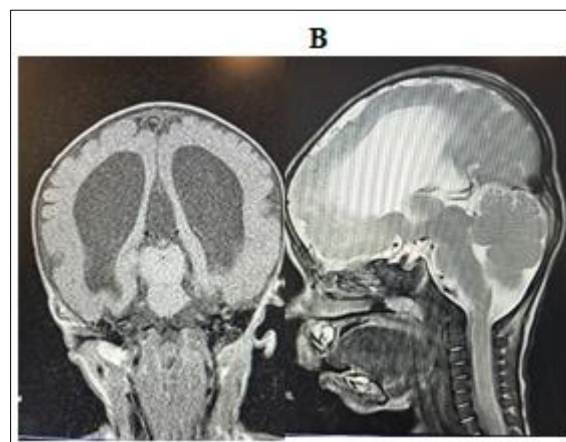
B: T1-weighted MRI coronal image showing bilateral frontoparietal and temporal lissencephaly and T2-weighted MRI sagittal image showing absence of septum pellucidum respectively
